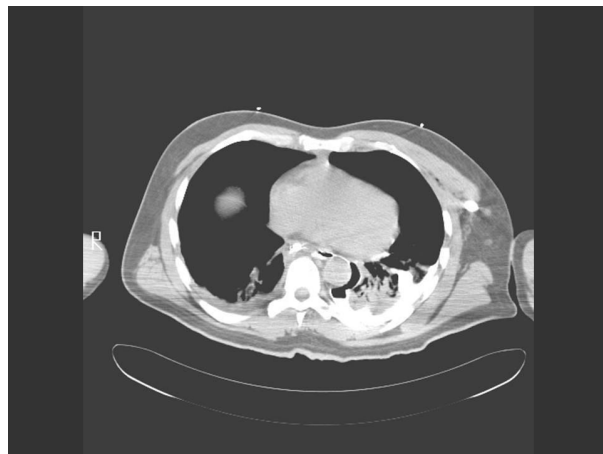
Computed Tomogram (CT) of the Chest
